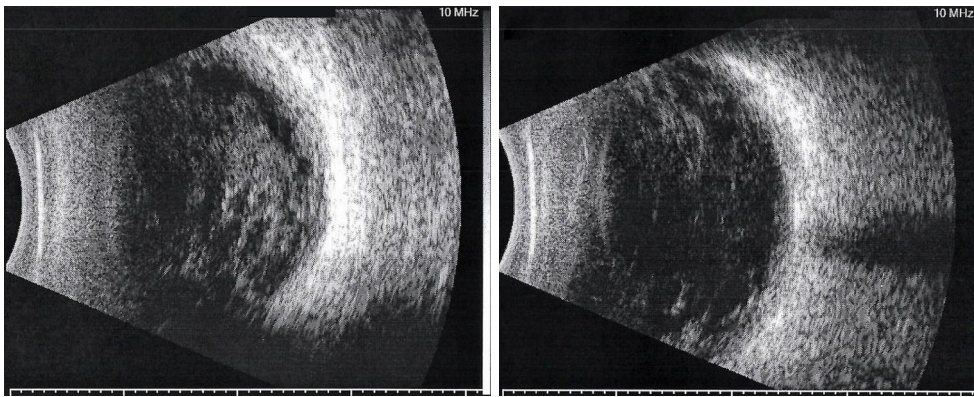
Bilateral ocular ultrasound (vitreous opacification).
